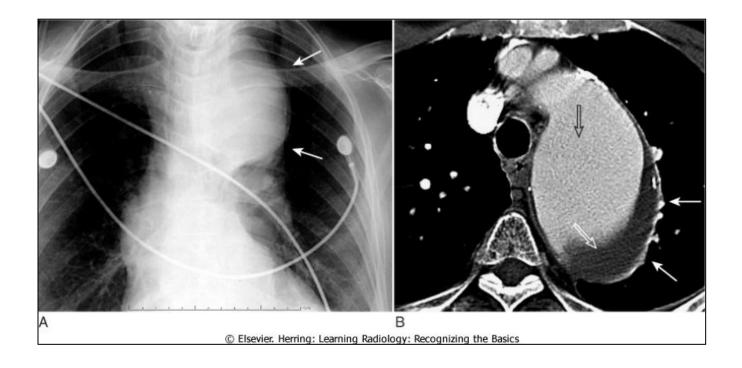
Aortic aneurysm, conventional chest radiograph and CT. Close-up view of a frontal radiograph of the chest (A) demonstrates a large mediastinal soft tissue mass with a calcified rim (closed white arrows). This soft tissue density represents a large aneurysm of the proximal descending aorta seen also in the CT scan to the right (B). The aneurysm measured 6.7 cm, which placed it at significant risk for rupture. Calcification in the wall of an aneurysm is common (closed white arrows). Contrast material mixes with blood flowing in the lumen of the aorta (open black arrow), but the flowing blood is separated from the intimal calcification (closed white arrows) by a considerable amount of non-contrast-containing thrombus adherent to the wall (open white arrow).
